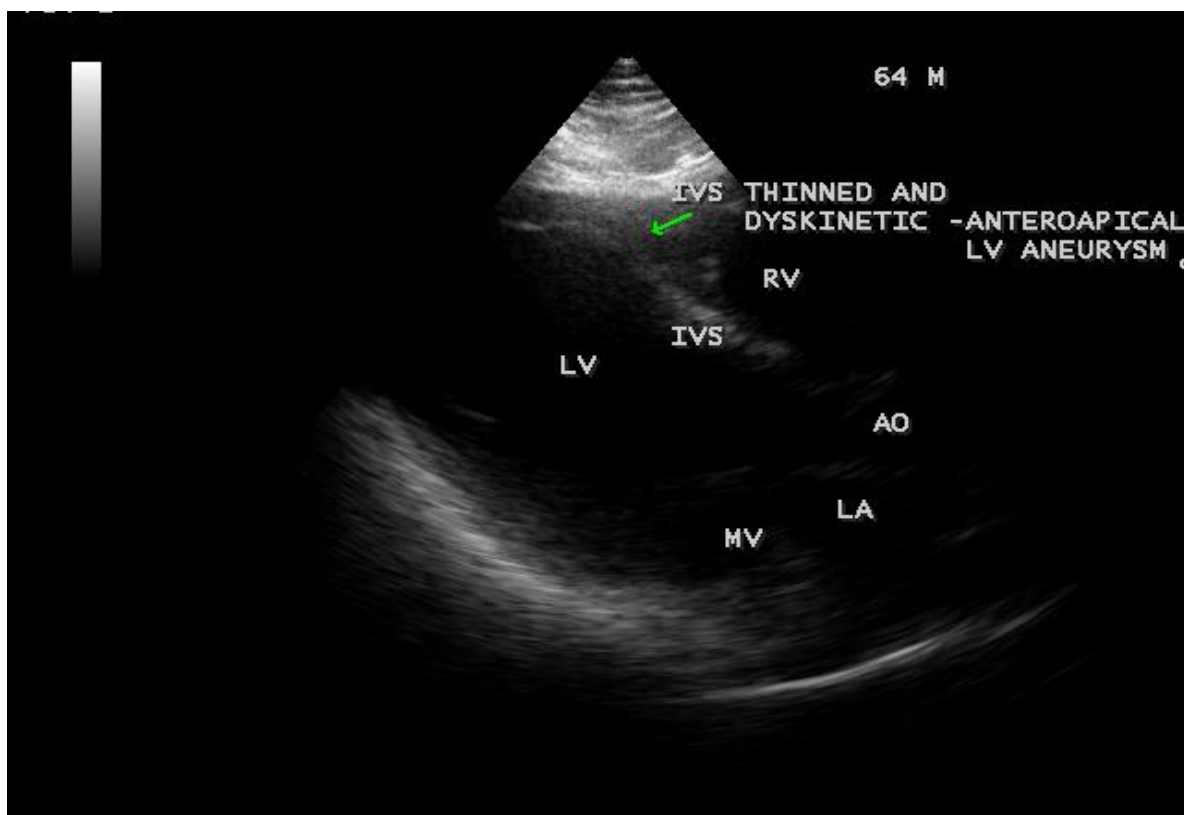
Parasternal long axis view showing the thinned out anteroapical septum.
